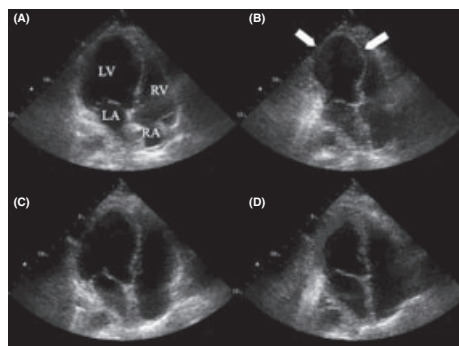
Transthoracic echocardiogram in the apical four-chamber view. Left images are in diastole. Right images are in systole. (A, B) Initial echocardiographic evaluation. In the systolic phase, mid-apical akinesia of the left ventricle in the systolic phase is shown by arrows. (C, D) Control echocardiogram after 1 day. (D) Akinetic segments returned to normokinesia.
